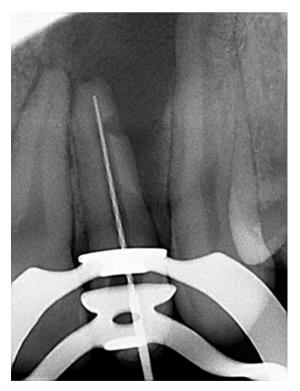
Radiographic working length measurement.
